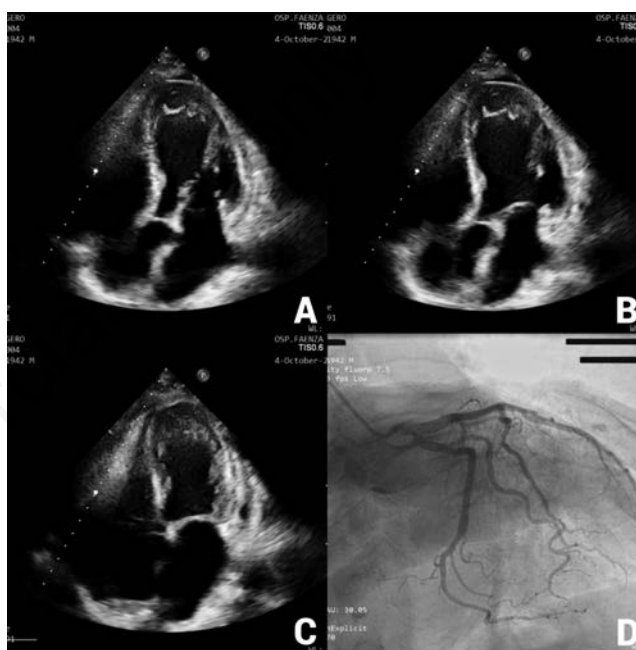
Echocardiographic (A, B and C) and coronographic images (D) of the present case showing the typical left ventricular apical ballooning.
